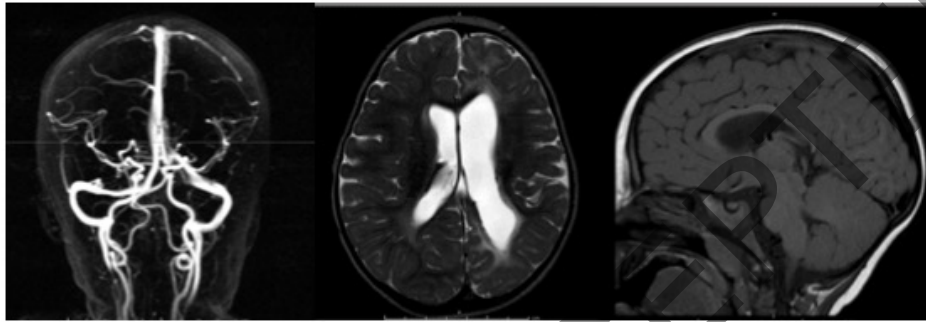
Brain MRI of our case at diagnosis: The MRI image shows a complex vascular malformation characterized by ectatic venous structures with aneurysmal dilatation in direct communication with the posterior cerebral and choroidal arteries in the region of left lateral ventricle. In the left occipito parietal hemisphere a ulegyric aspect of cerebral gyrus and ex-vacuous dilatation of the left lateral ventricle was also noticed. Figure 1b Brain MRI after two embolization treatments: In this MRI the ectatic venous structures are not recognisable. There is persistence of the ex-vacuous dilatation on the left lateral ventricle.
